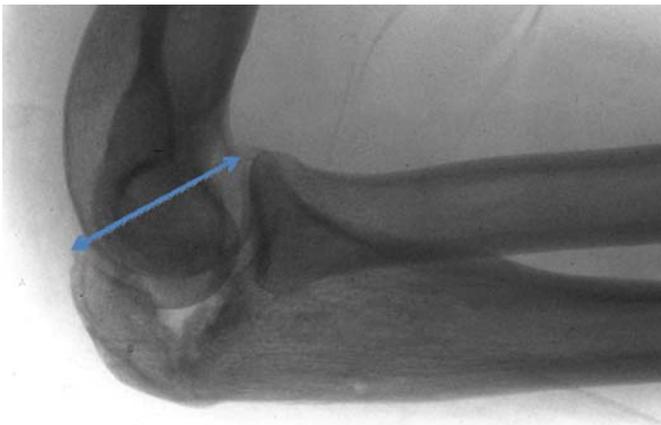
Lateral xray of the patient showing the olecranon malunion with a large osteochondral defect and shortened coronoid-to-olecranon interval (blue arrow).
